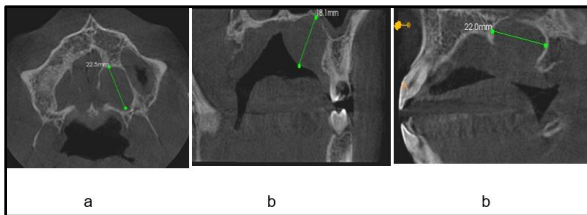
CBCT Photographs
